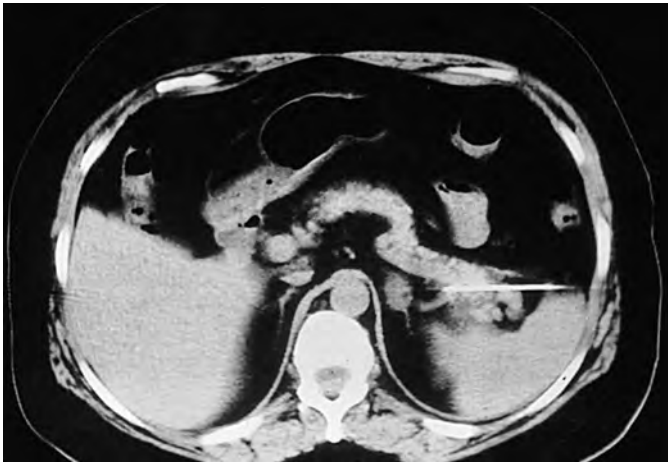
CT of a 48-year-old woman with breast carcinoma. Axial CT of the upper abdomen with contrast material reveals a small nodule in the left adrenal gland. The right adrenal gland was normal. The left adrenal mass underwent biopsy percutaneously through an intercostal and transpancreatic approach. Because normal pancreatic parenchyma is prone to development of pancreatitis when it is transgressed, this technique is not recommended. Fine-needle aspiration revealed no evidence of malignant transformation.
